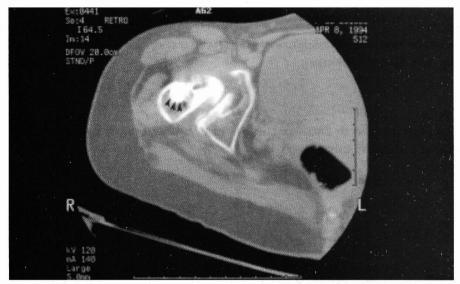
CT scan demonstrates intramedulary position of the retained hardware (arrows).
